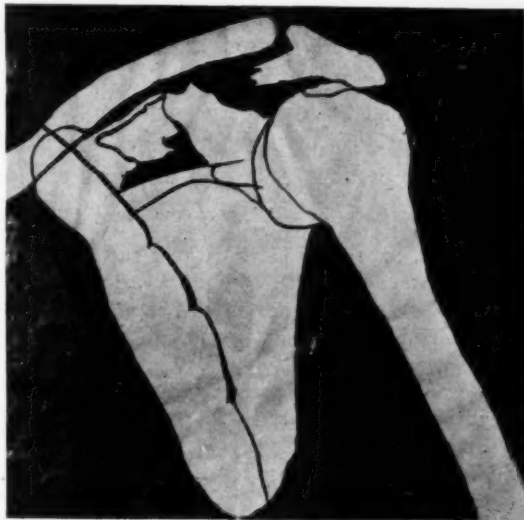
M. O., male, aged twenty-five. Fell four stories from a scaffold after a brick had fallen on his head. On admission the patient was unable to raise the arm and had pain and tenderness in the scapular region. Besides the fractured scapula, there were the following injuries: Fracture of the skull, cerebral concussion, laceration of the scalp, abrasions of the face and contusion of the shoulder. The above X-ray tracing demonstrates a complete fracture of the acromion with separation of about half an inch, also a fracture of the body just above the spine. The patient was kept in the hospital in bed for twenty-two days because of his other injuries. He received physiotherapy, i.e., massage, active and passive motion of the arm and shoulder, but no further treatment for the fractured scapula. The hospital result was considered only fair. The final result was also fair as a three months' follow-up showed some irregularity of the acromion and some limitation of motion of the shoulder.
